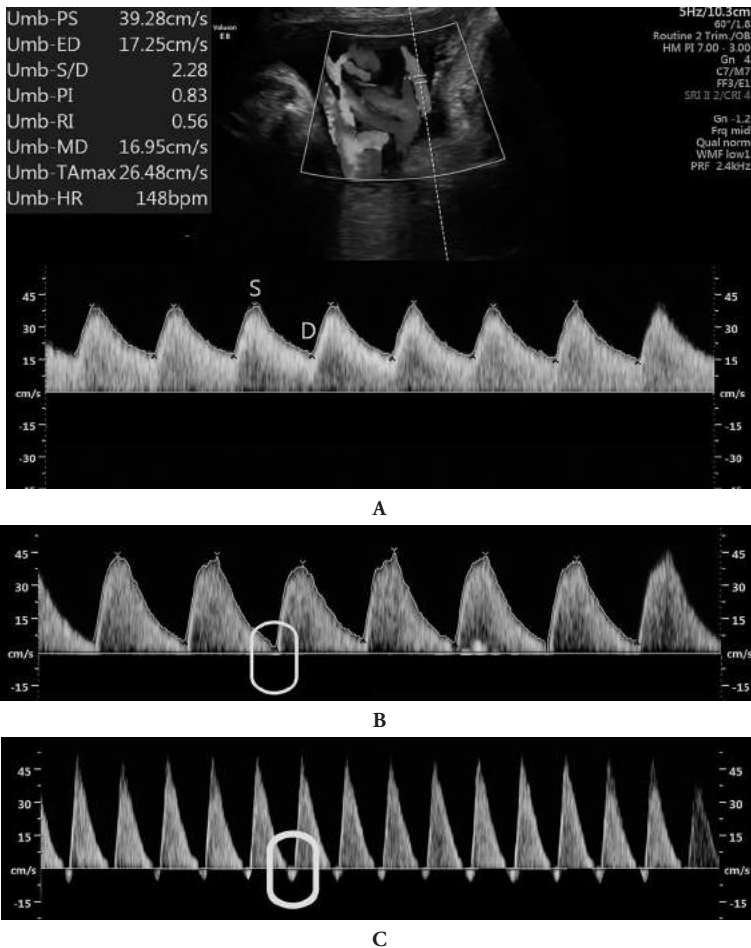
A: Doppler of fetal umbilical artery (good forward flow in systole and diastole)—low resistance (normal placenta). B: Doppler of fetal umbilical artery (decreased forward flow in diastole, increase in S/D ratio, pulsatility index [PI])—placental insufficiency. C: Doppler of fetal umbilical artery (reversal of flow in diastole)—severe placental insufficiency.
